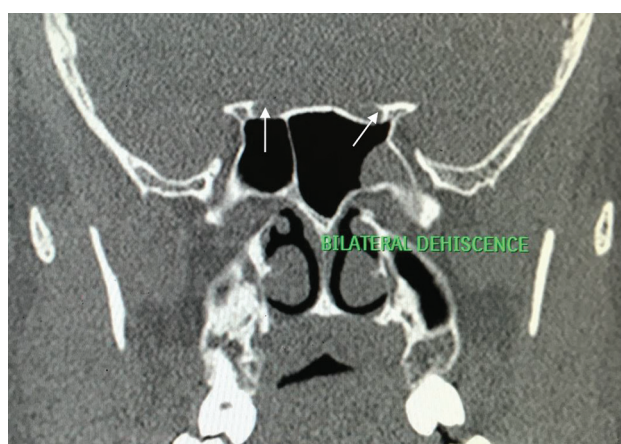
Coronal CT image of a 33-year-old male showing bilateral bony dehiscence (white arrows).
